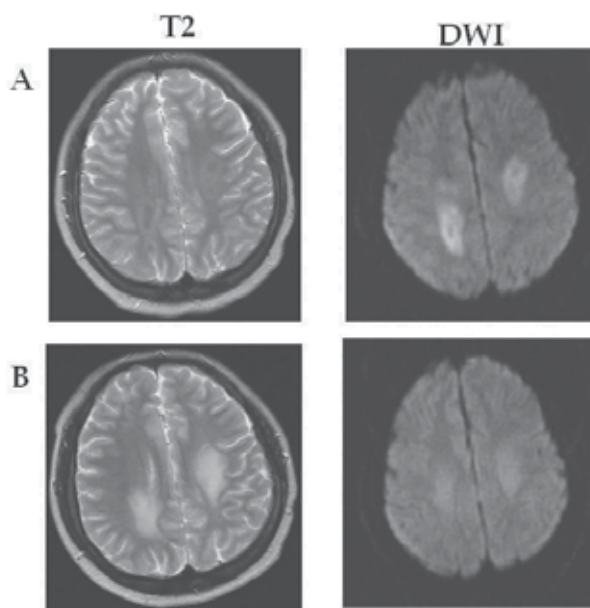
Brain MRI in a patient with acute MTX toxicity. A. At time of initial diagnosis, hyperdense lesions are noted bilaterally on DWI in the centrum semiovale. B. Two months later. The patient's symptoms (seizures, paralysis) resolved.
